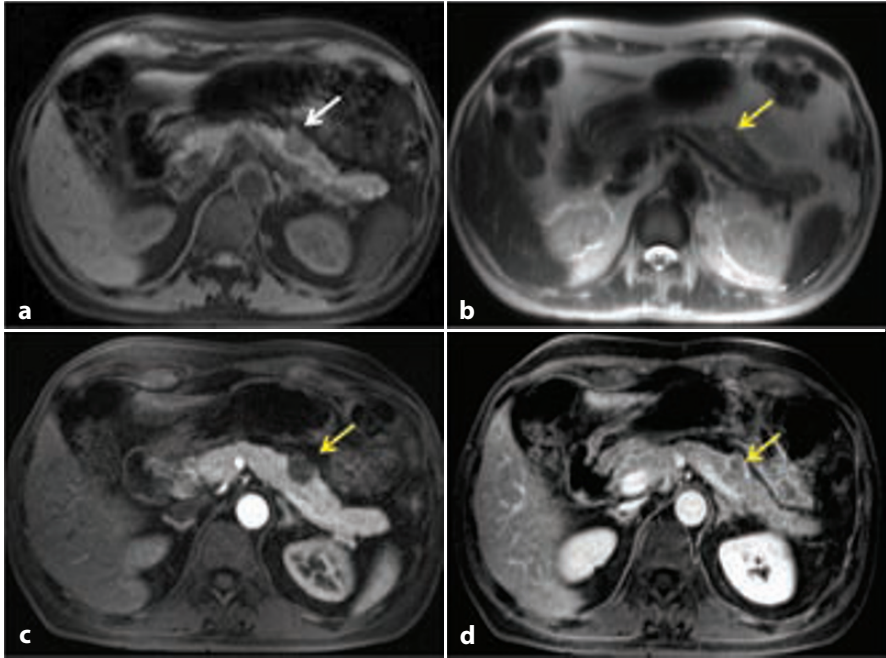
Atypical delayed enhancement of a PanNEN of the pancreatic body. A relatively small NF-PanNEN is hypointense on the pre-contrast T1-weighted image (a) and slightly hyperintense on the T2-weighted image (b). The tumor is hypovascularized during the arterial pancreatic phase (c) but shows delayed enhancement, resulting in an isointense lesion with a thin hyperintense rim on the enhanced axial image acquired at the time of late venous phase (d)
